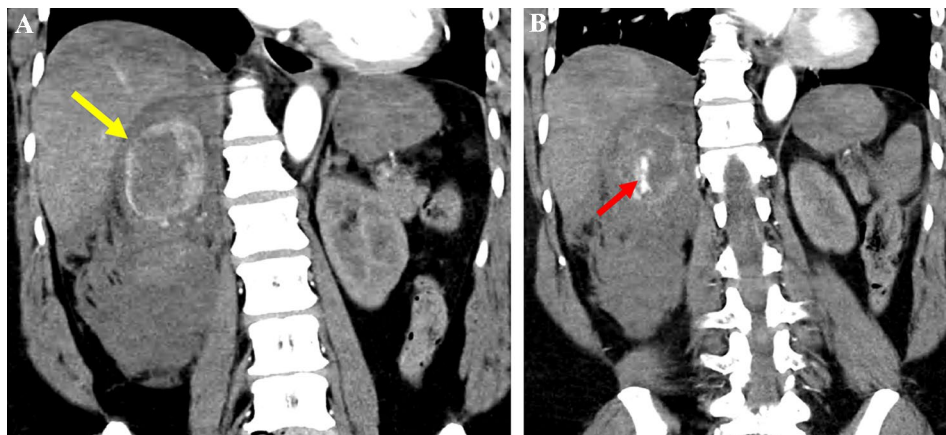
Coronal venous phase contrast-enhanced CT images show an incidentally detected right adrenal pheochromocytoma (yellow arrow in A) that ruptured with active bleeding (red arrow in B) following a motor vehicle accident
